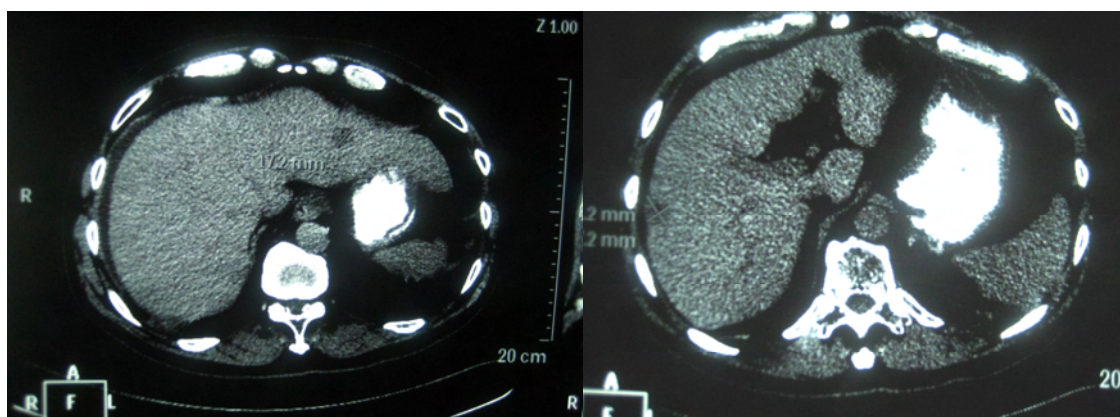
CT images showing the hypodense lesions, one in each lobe of the liver
